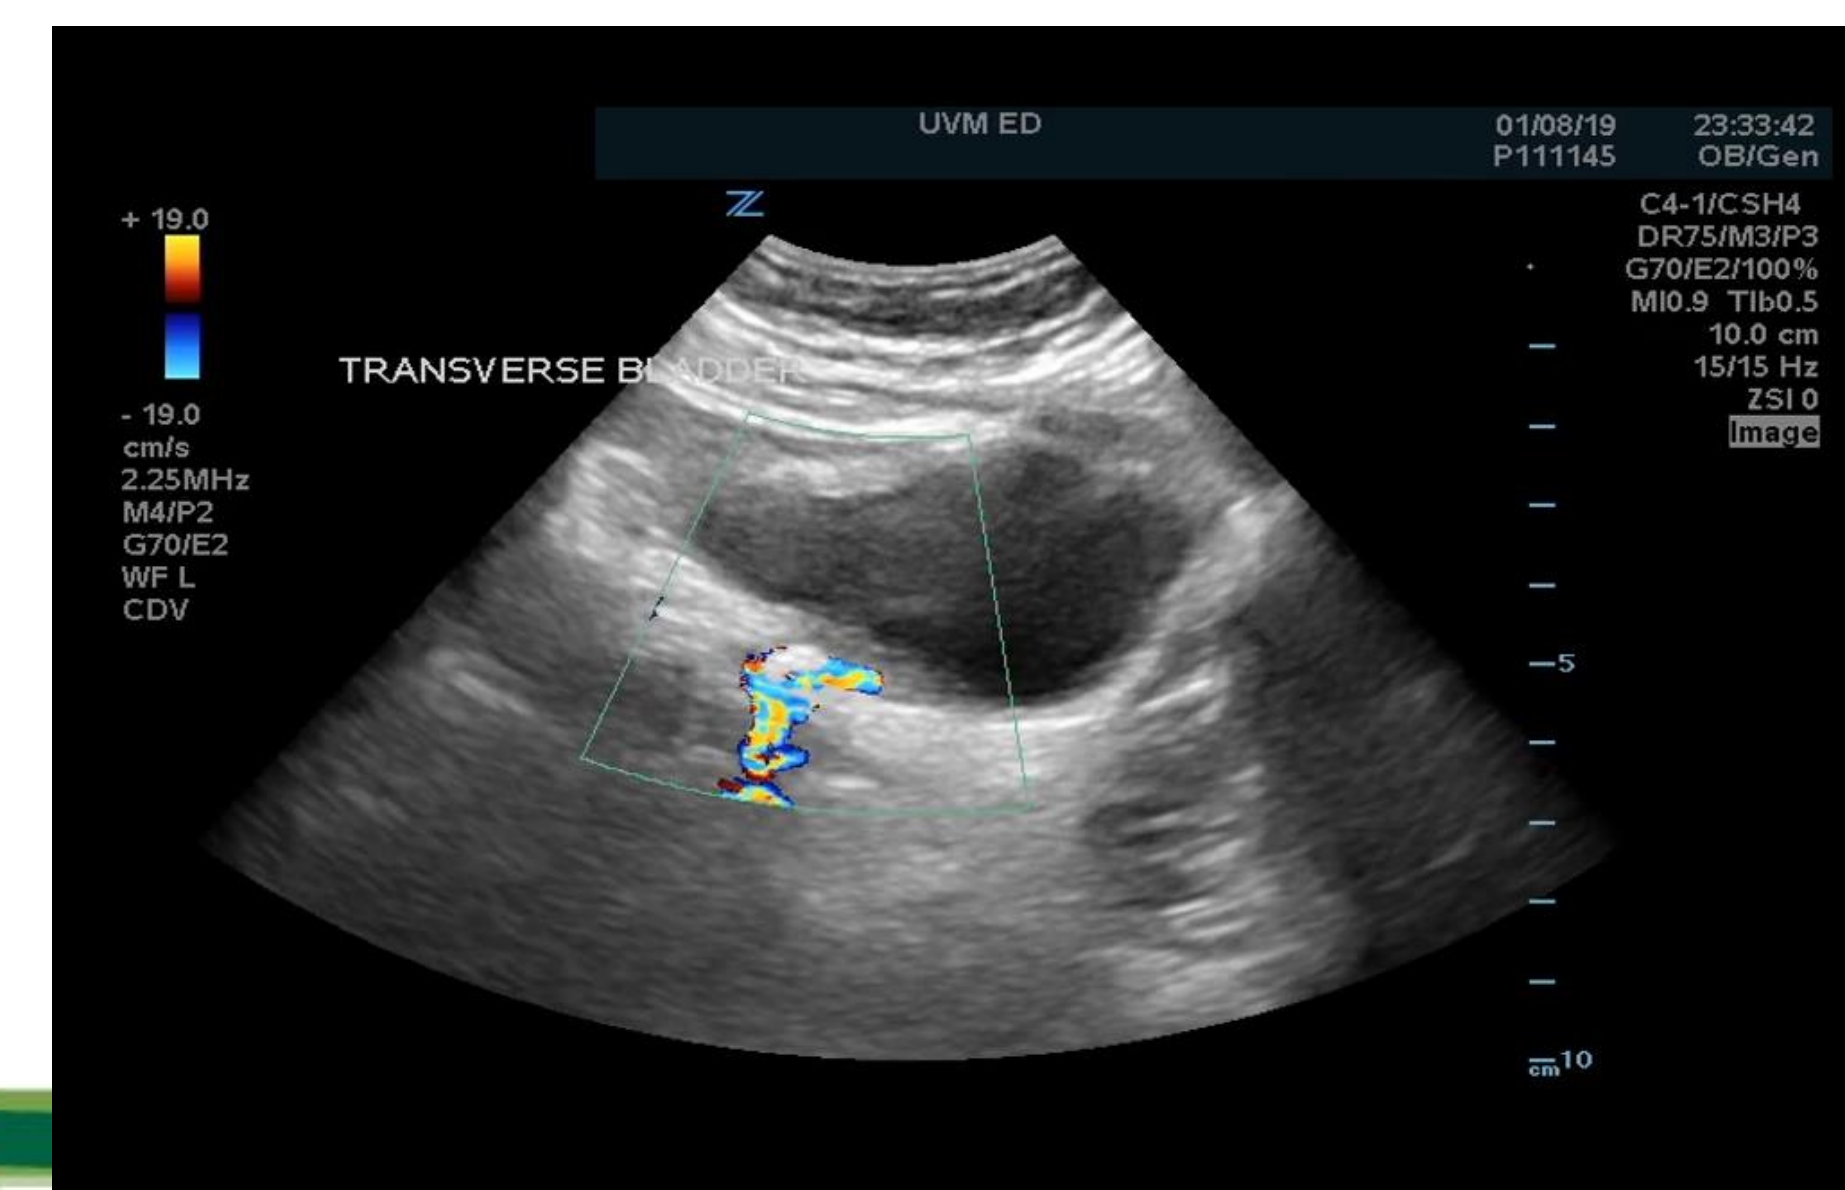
Ultrasound of the bladder showing a ureteral calculus with partial obstruction of outflow.
